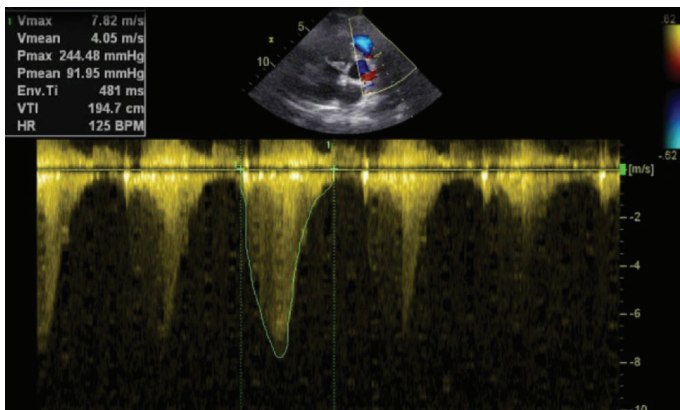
Gradient measurement from pulmonary artery with cw on echocardiography. In echocardiography; PV max 7.1 m/sec, severe pulmonary stenosis, pulmonary gradient was determined as 244/91 mmHg.
